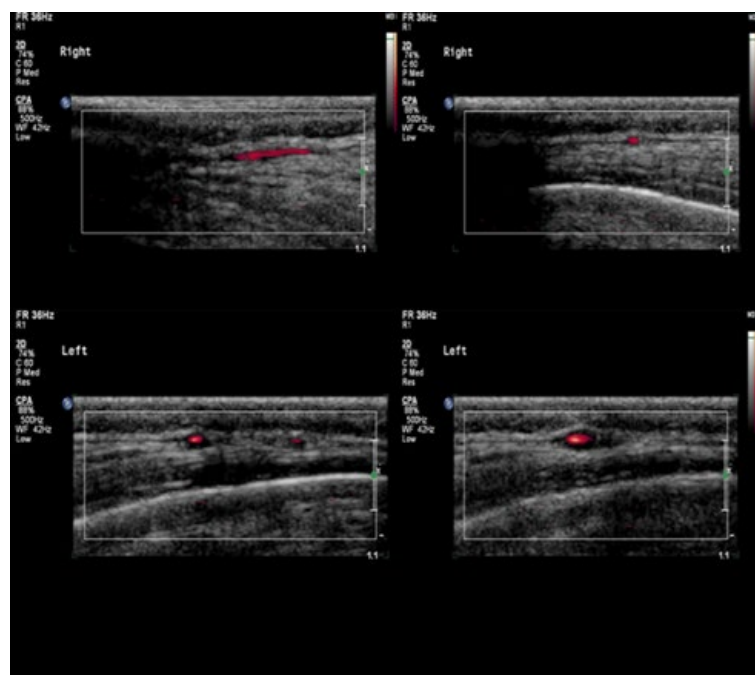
Colour Doppler ultrasound examination of a normal and an affected temporal artery in giant cell arteritis.
